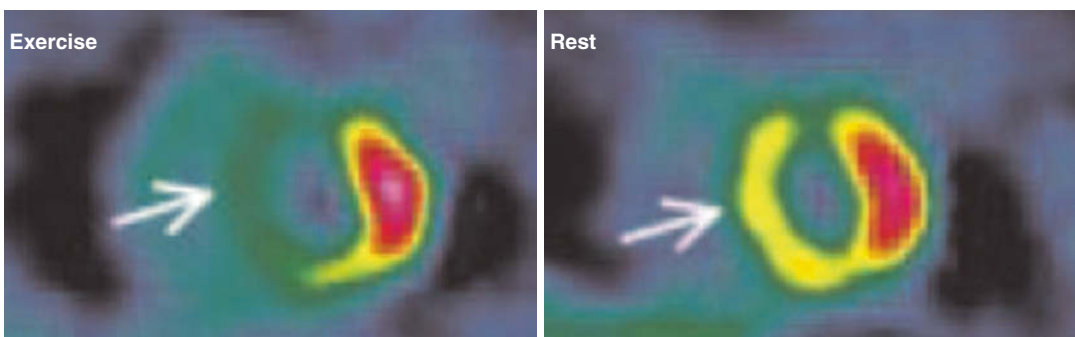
Single-photon emission computed tomography (SPECT). SPECT can be used to evaluate myocardial perfusion and viability to assess inducible ischemia due to flow-limiting coronary stenosis. This is achieved by intravenously administering minute levels of radioactive trace
